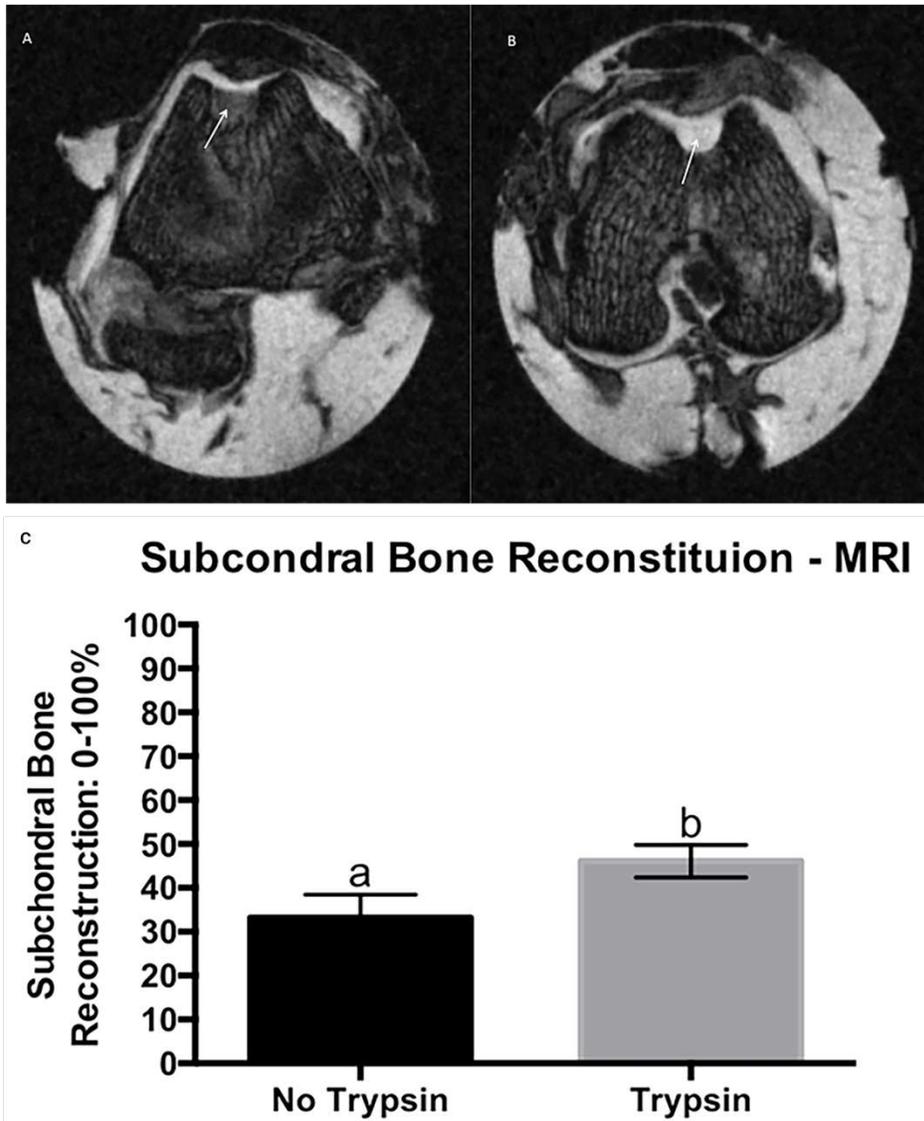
Transverse PDFS MRI image showing improved subchondral bone reconstitution (arrows) of the reparative tissue treated with trypsin (B), compared to its contralateral control (A), MRI score for main effect of trypsin on subchondral bone reconstitution, grading scale 0-100%, where 0% is no subchondral bone reconstitution and 100% is subchondral bone reconstituted to the level of surrounding tissue. Error bar represents standard error. Different letters mean statistical significant difference (C).
